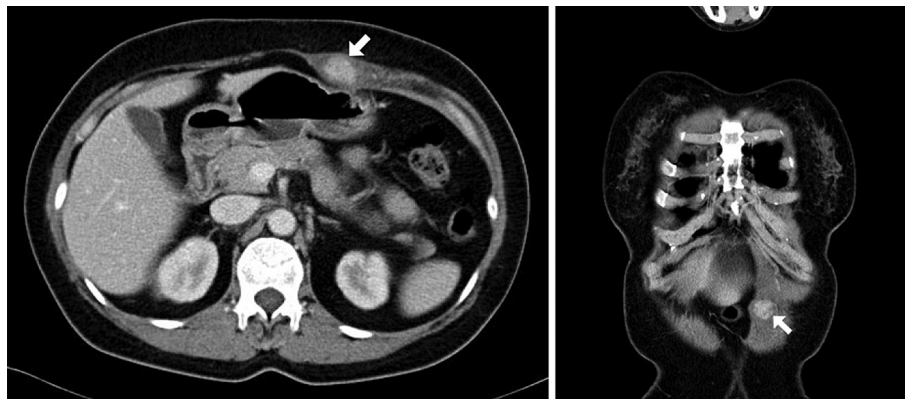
Computed tomography scans of the abdomen without and with IV contrast enhancement show an ill-defined enhanced lesion (approximately 2.4 cm) in the left rectus abdominis muscle. Hypervascular tumors, such as hemangiomas or other intramuscular neoplasms, were suspected.
